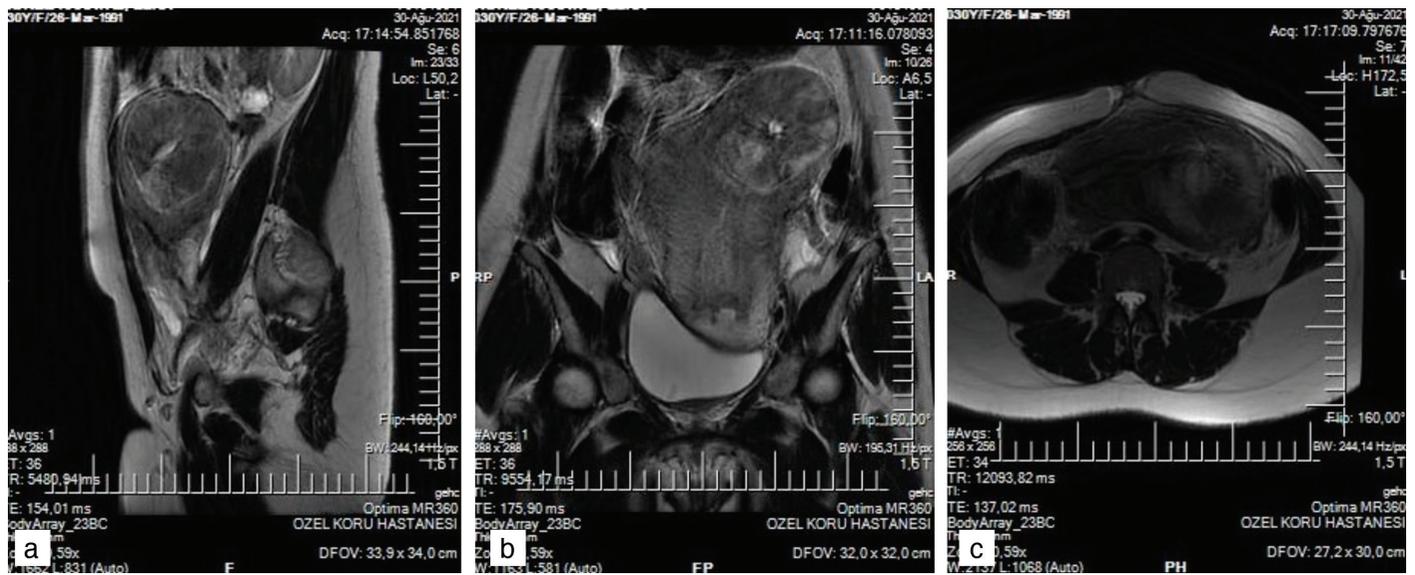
(a-c) Magnetic resonance imaging of the uterus with placenta postpartum 1st hours
